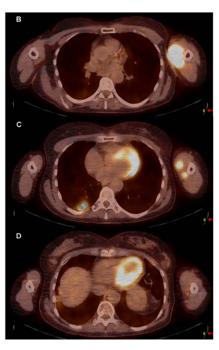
A. Attenuation-Corrected Positron Emission Tomography shows a mass in the left upper arm and a cavitating pulmonary nodule in right lower lobe. B. Fusion ¹⁸FDG-PET-CT shows an intense ¹⁸FDG-avid mass (6.0 cm diameter) in the soft tissue of the left arm. C. Fusion ¹⁸FDG-PET-CT showing a cavitating pulmonary nodule with PET-positive margins (2.9 cm diameter) and the lower part of the muscle metastasis. D. Fusion ¹⁸FDG-PET-CT shows a slight ¹⁸FDG-avid pulmonary nodule in the right lower lobe (7 mm diameter).
